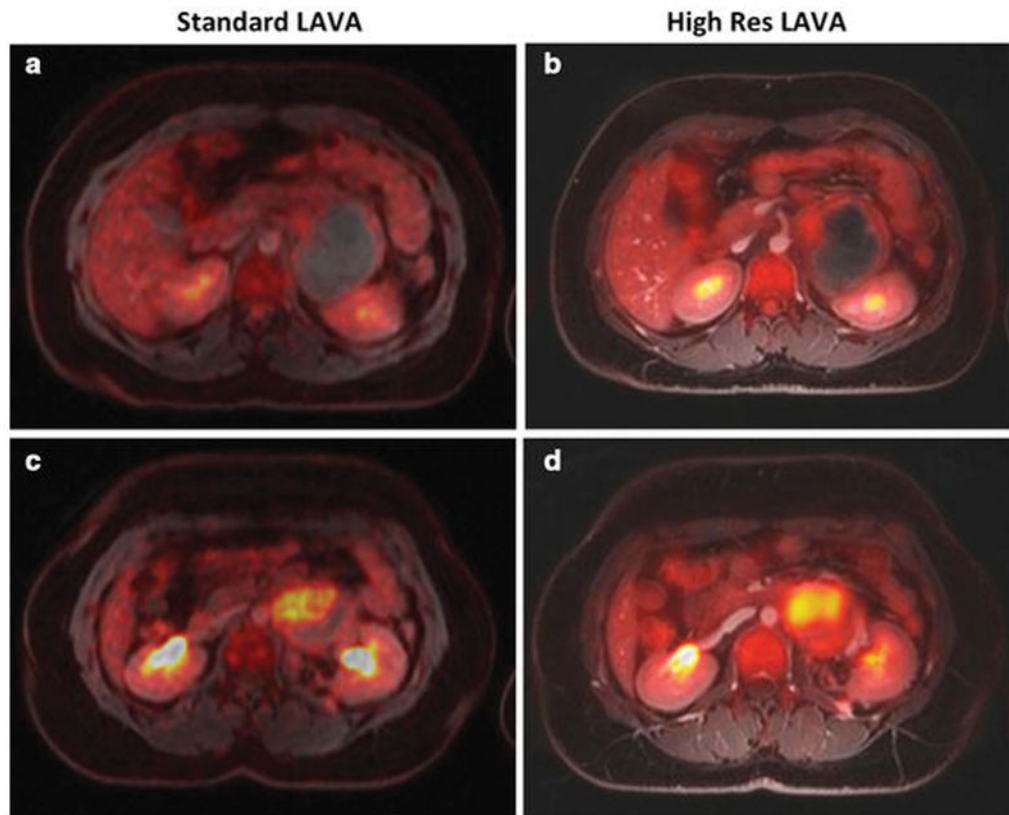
Spatial resolution on ^{18}F -FDG PET/MR is important to render accurate diagnostic information in a young adult with retroperitoneal soft tissue sarcoma
